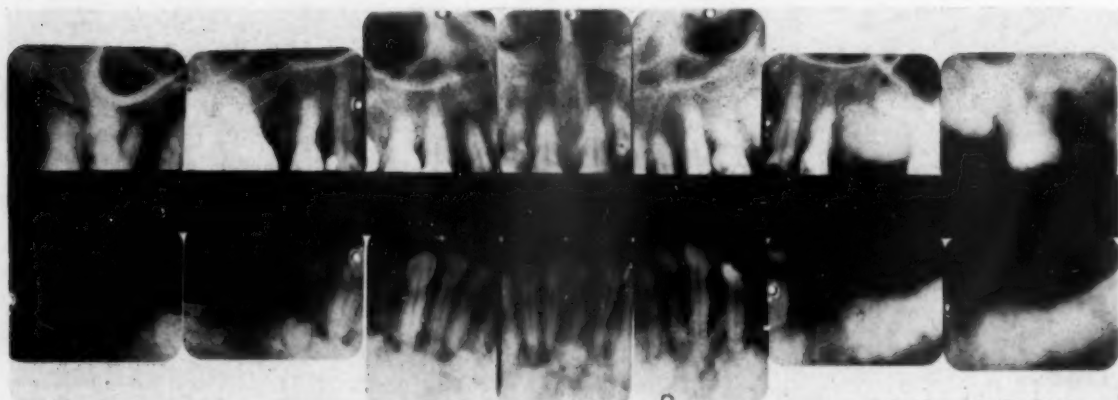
Case 3. Characteristic osseous changes associated with this disease revealed in a full-mouth roentgenogram.
